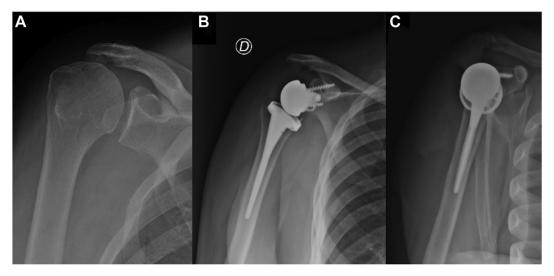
Preoperative radiograph before Reverse Shoulder Arthroplasty (A) and postoperative radiographs (B and C).
